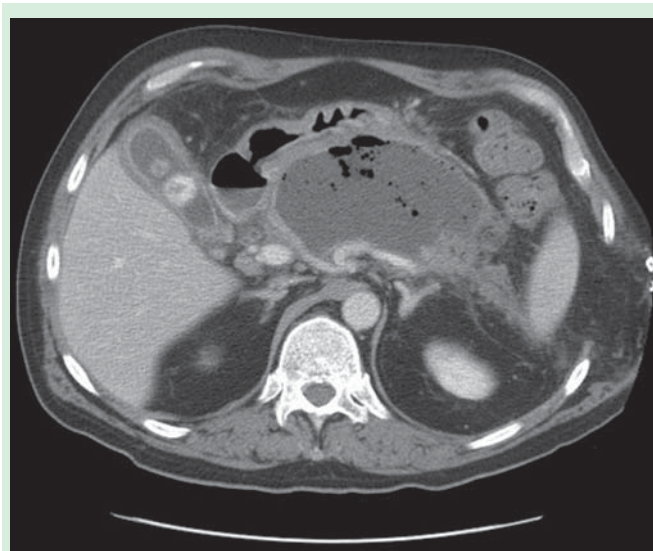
CT scan performed 6 weeks after admission demonstrating walled-off pancreatic necrosis with air bubbles indicating infection.
